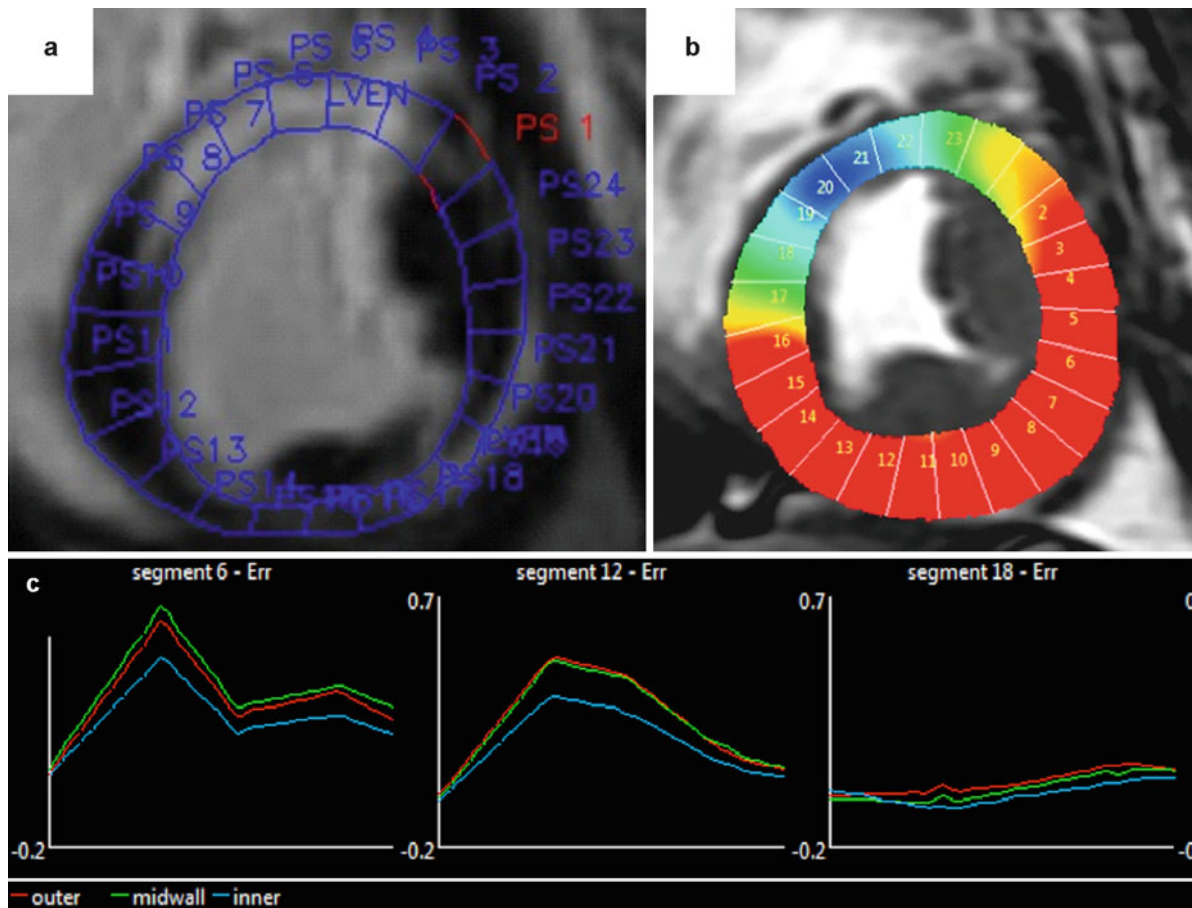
Tissue tracking for cardiac strain – Tracking of myocardial tissue contours from short-axis SSFP images is demonstrated in a patient with anteroseptal myocardial scar. (a) Short-axis delayed enhanced MRI image of myocardial scar divided in 24 segments. (b) Color-coded radial strain plot generated from a non-tagged MRI cine showing contraction (*red*) in viable myocardium and simultaneous
